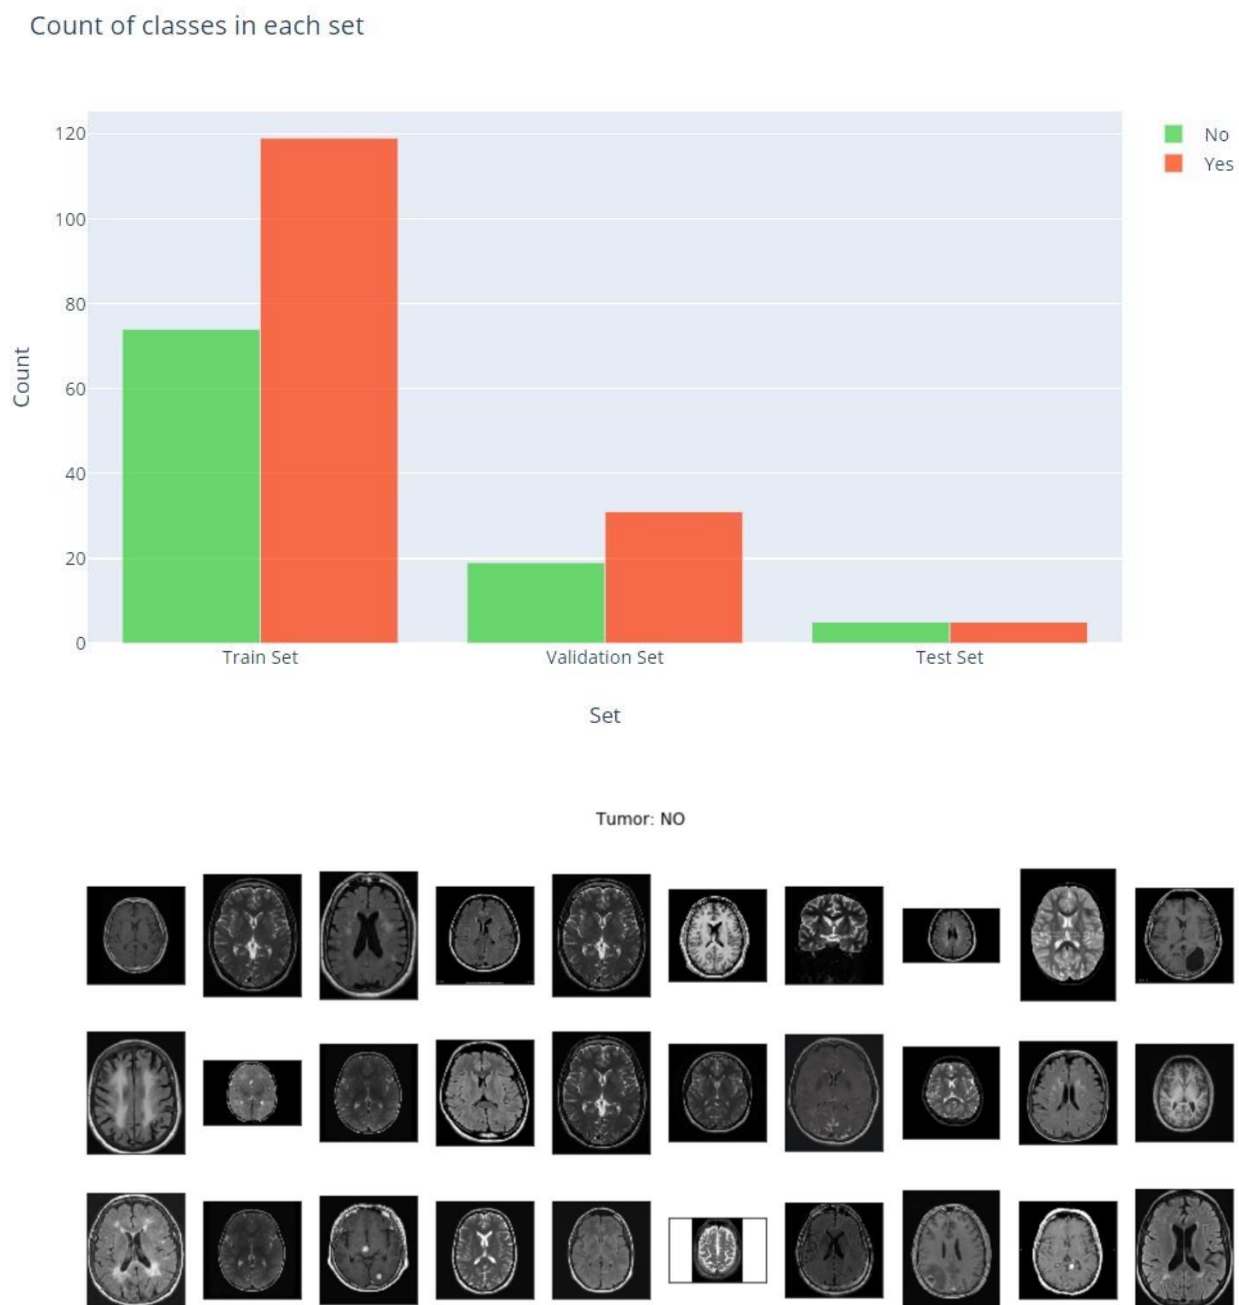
MRI of Brain without Tumor
